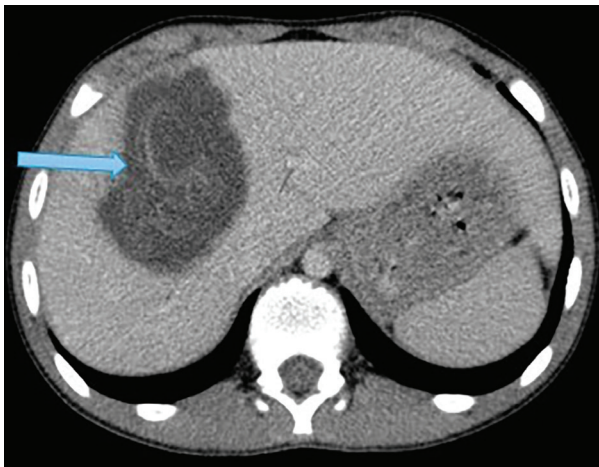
In a 22-year-old foreign man, axial computed tomography imaging showed a cystic lesion in the right liver lobe with a detached membrane (arrow), confirming hydatid cyst.
